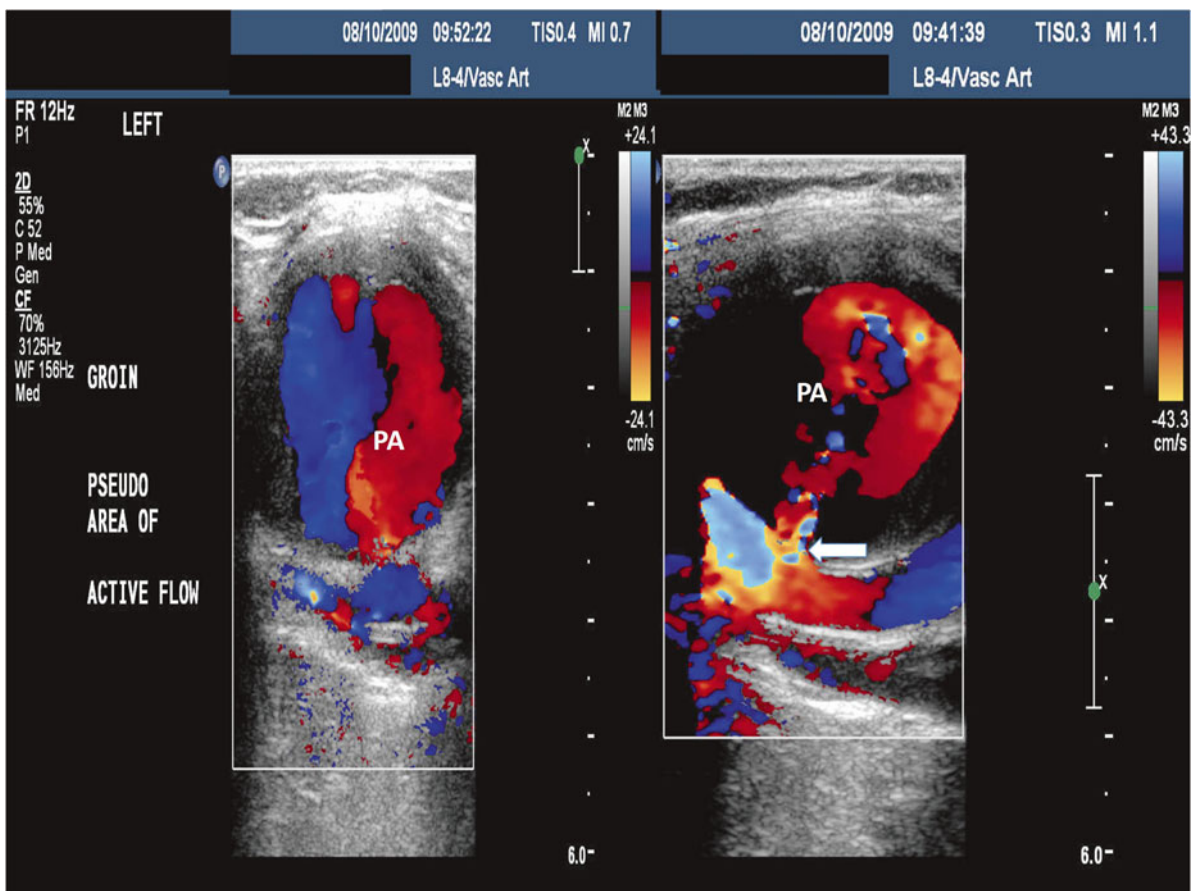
Duplex ultrasound showing a femoral pseudoaneurysm (PA) in two views with the right panel demonstrating the defect in the artery (arrow)
